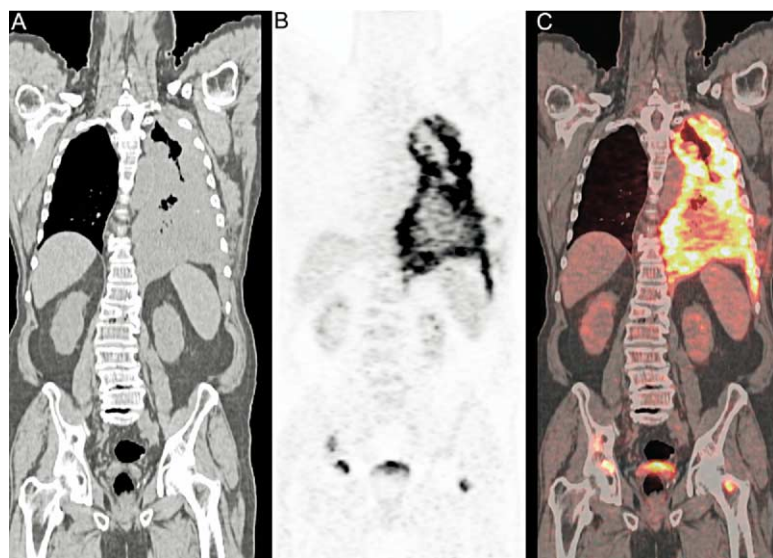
Coronal CT (A), PET (B), and integrated CT-PET (C) show diffuse uptake of FDG in primary left pleural tumor and focal areas of increased uptake in the pelvis localized to right iliac bone and left femoral neck. These occult metastases were not detected on conventional staging evaluation.
